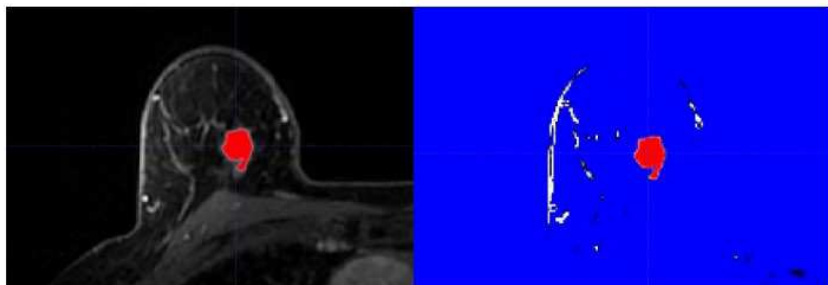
Segmented Tumor ROIs on pre-NAC MRI scans using ITK-SNAP software
